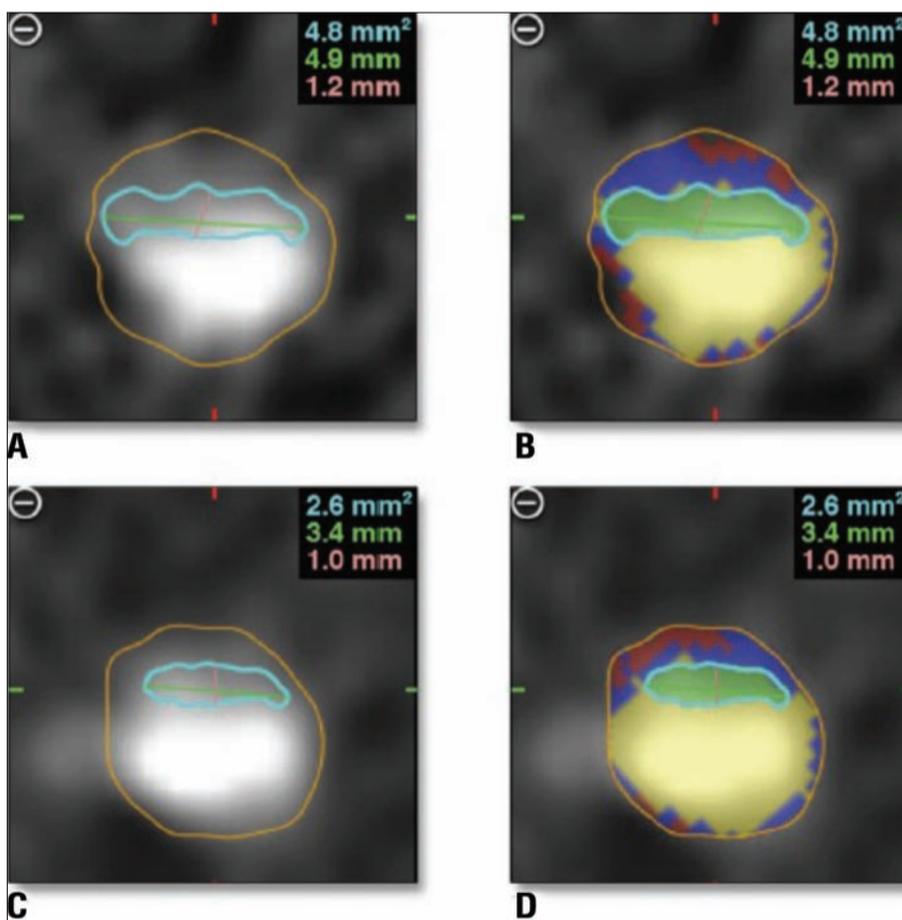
Quantitative measurement of coronary plaque progression by coronary CTA, similar to VH
